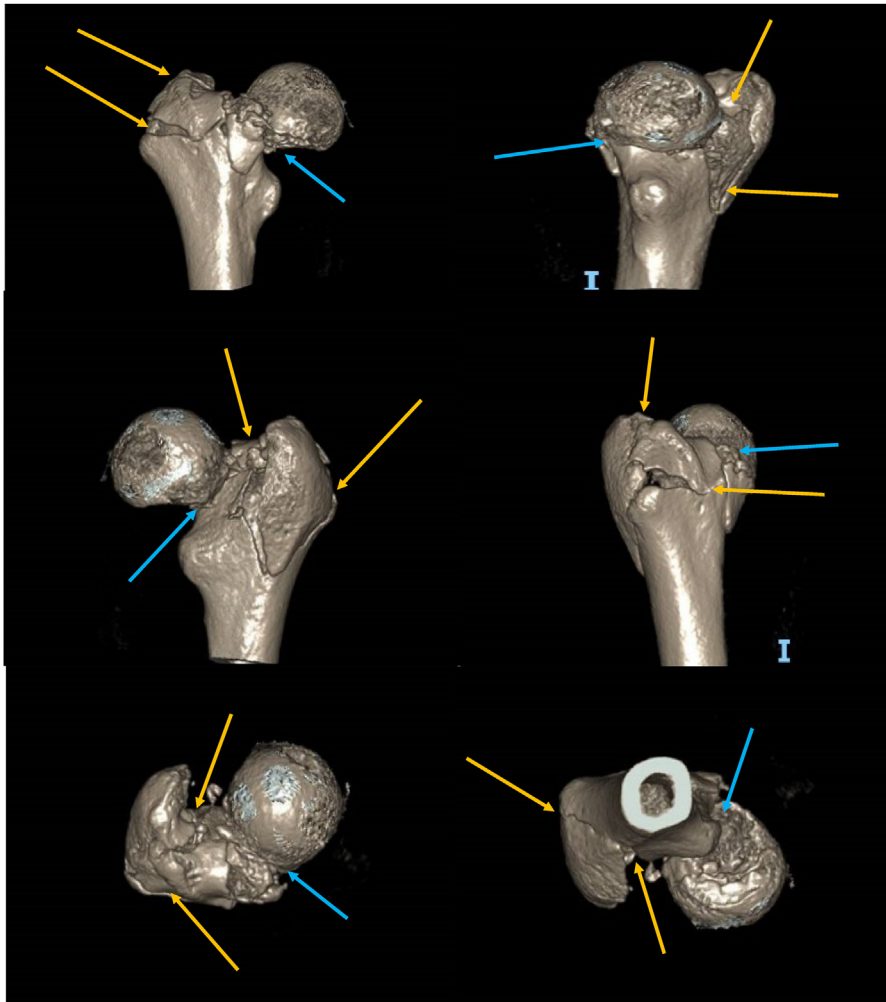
Three-dimensional CT proximal femur. Blue arrows point to subcapital (intracapsular) fracture. Yellow arrows point to trochanteric (extracapsular) fracture.
